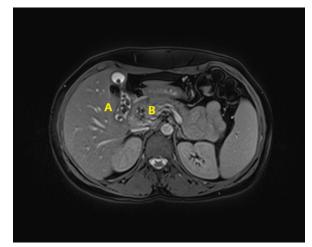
Magnetic resonance imaging shows the gallbladder and common bile duct (A indicates the gallbladder with stones, and B indicates the common bile duct with stones).
